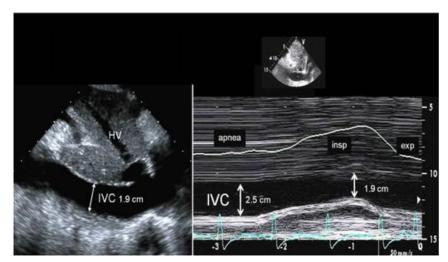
Two-dimensional subcostal view of the heart in a patient with cardiac tamponade showing a dilated IVC (2.5 cm) by 2D echocardiography and M-mode of the IVC throughout a respiratory cycle. The M-mode recording is used to calculate the inspiratory reduction in diameter as shown. With tamponade, the inspiratory decrease in IVC diameter is characteristically <50%, as seen in this case, and is often minimal. Note also the dilation of the hepatic veins (HV).
